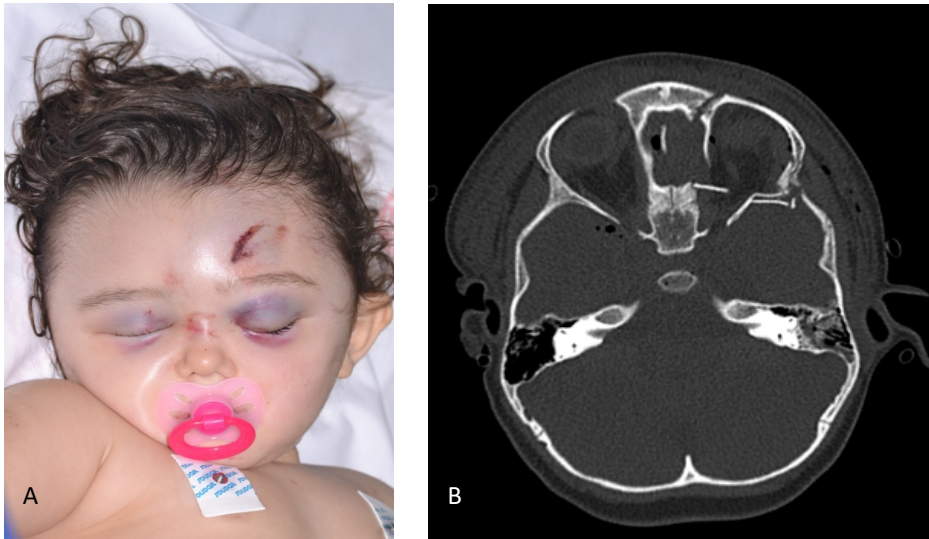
Preoperative findings. (A) Clinical photograph showing bilateral periorbital ecchymosis and the site of frontal impact. (B) Axial computed tomography (CT) scan demonstrating a displaced left orbital roof fracture with compression of the optic nerve.
